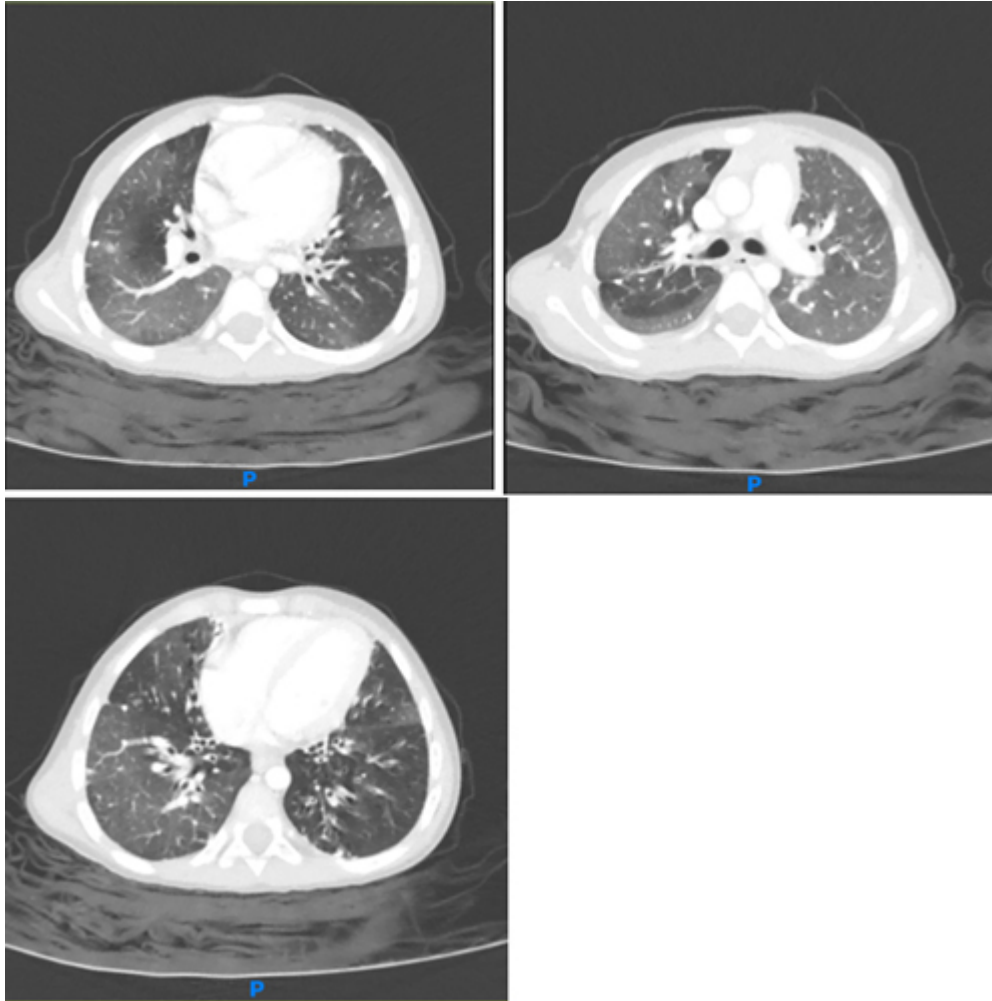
CT at age 4 years. ↩
